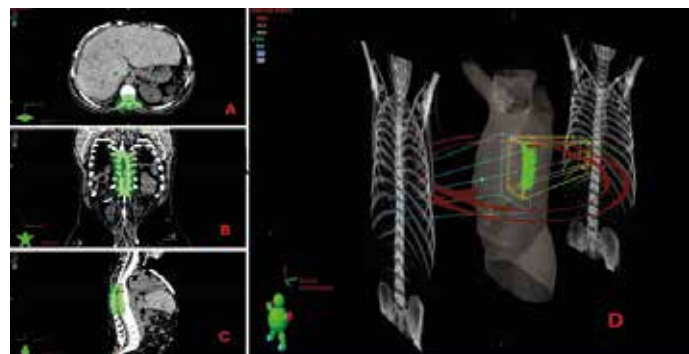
Radiotherapy treatment planning axial, coronal and sagittal CT -images showing targets and radiation dose clouds at 95% isodose level (A, B, C). 3-D representation of room eye view of the target and beam geometry by VMAT technique. (D)
